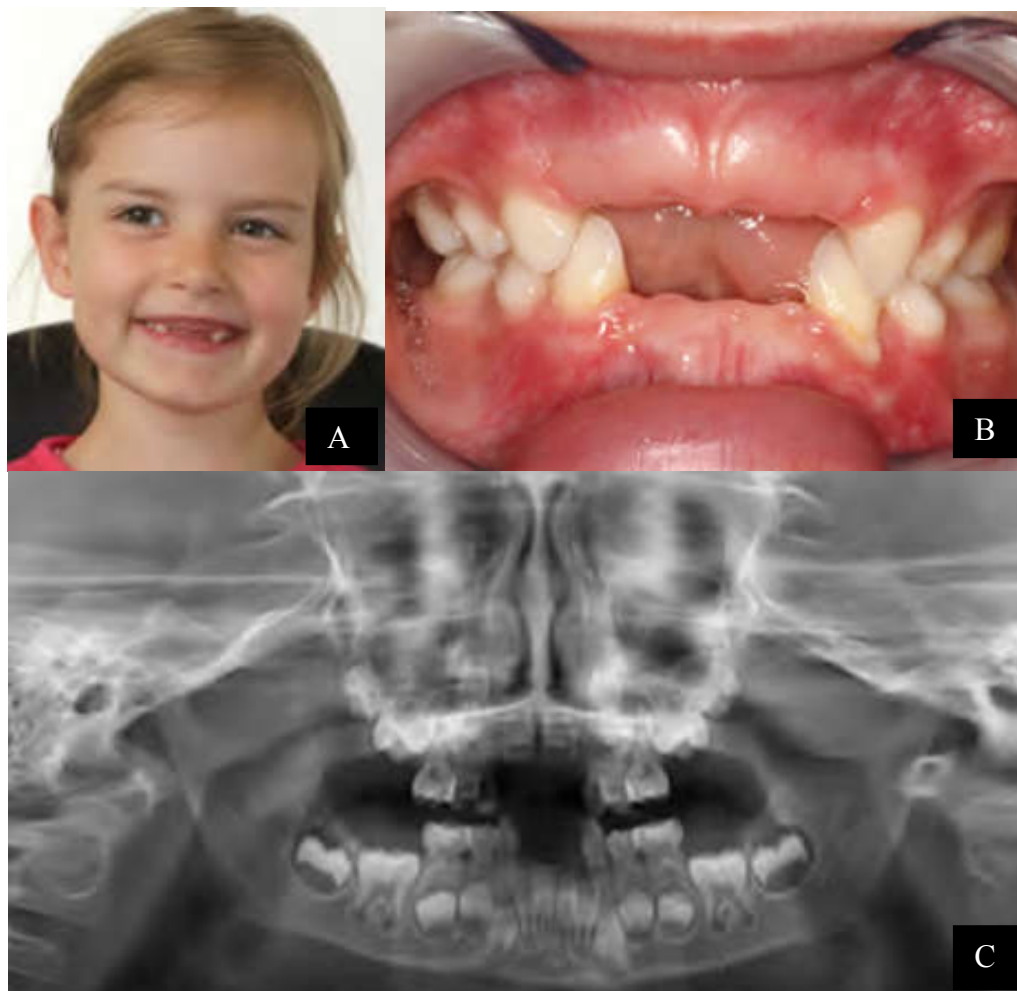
Photograph and X-ray of Case # 3: This is a girl aged 3 years with PPH (35)
